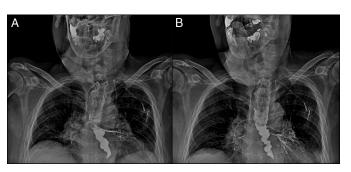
Upper gastrointestinal x-ray showing passage of contrast from the esophagus to the main left bronchus (A, B).
